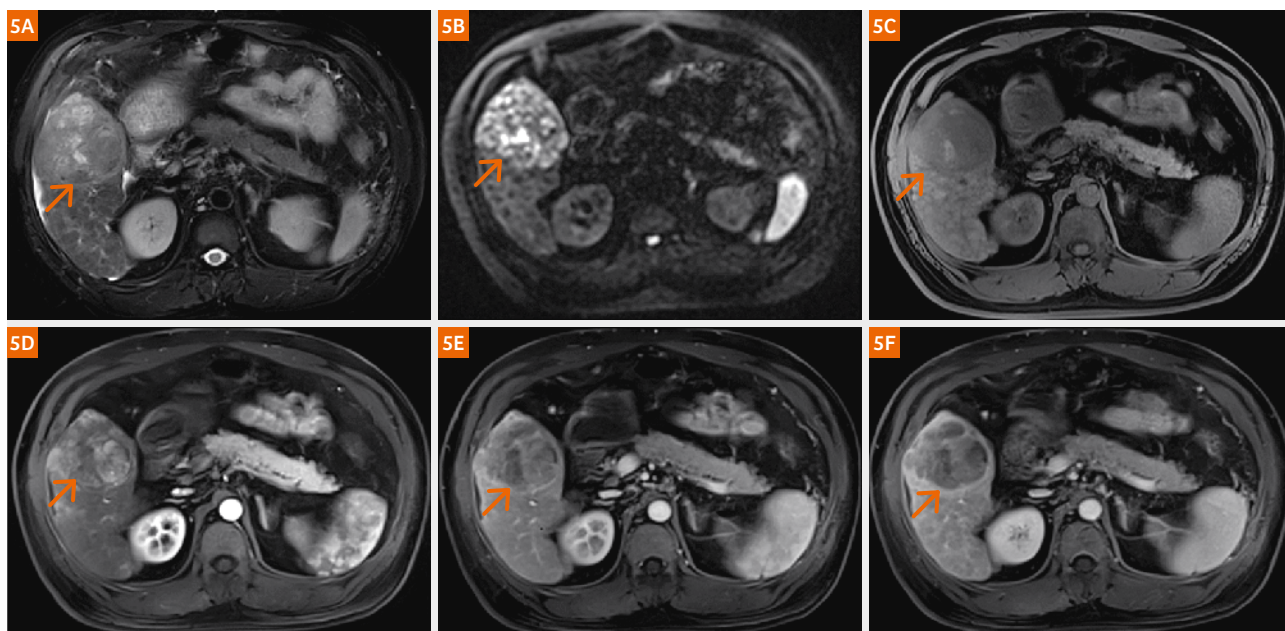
Large HCC in a 43-year-old man with cirrhosis resulting from hepatitis B: The axial T2-weighted MR image (5A) and DWI with b = 1000 s/mm² (5B) show a heterogeneous mass (arrow) with high signal intensity in the right lobe bordering the liver capsule. The axial T1w image (5C) shows the mass as hypointense (arrow). The axial T1w image (5D) obtained in the arterial phase shows heterogeneous hypervascular enhancement of the mass (arrow). The axial T1w images obtained in the venous and delayed phases (5E, F) show washout (arrow). A thin circumferential hypointense rim is visible around the periphery of the tumor, a finding which is indicative of a capsule, with typical late enhancement after administration of a gadolinium-based contrast medium.
